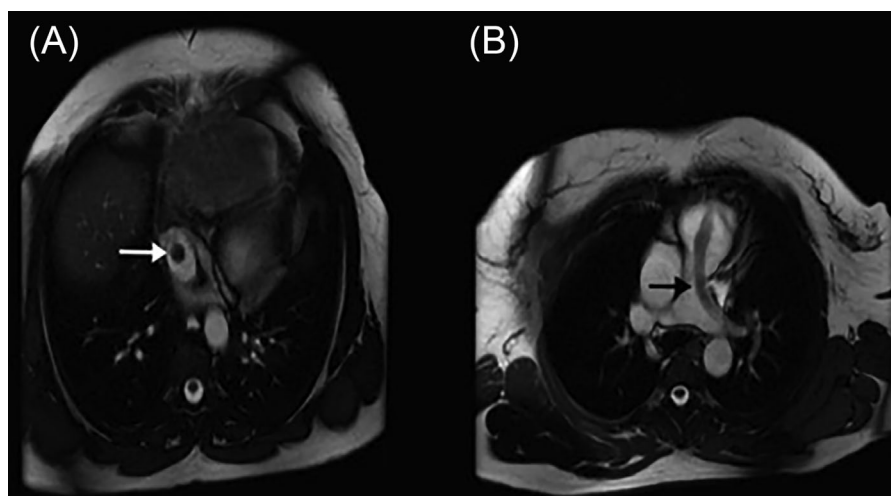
Axial plane thoracic magnetic resonance imaging with contrast revealed (A) tumor mass in the vena cava inferior (white arrow) and (B) the extension of the tumor to the left pulmonary artery (black arrow)
